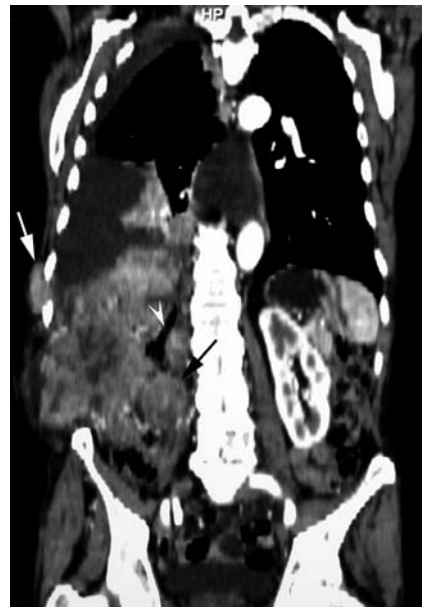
Local recurrence, chest wall, and pleural metastases in a 72-year-old man who underwent right nephrectomy for renal cell carcinoma. a Axial contrast-enhanced CT scan shows a large heterogeneously enhancing mass with central necrosis of the right renal fossa, extending posteriorly towards the surgical scar and invading the right latissimus dorsi muscle (arrow). It also shows a small heterogeneous mass of the lateral right chest wall (arrowhead). b Coronal contrast-enhanced two-dimensional CT reconstruction shows the large recurrent renal cell carcinoma mass that is locally and directly invading the ascending colon (arrowhead) and the right psoas muscle (black arrow). It also shows the right chest wall mass (white arrow) and important right pleural and pericardial effusions.
